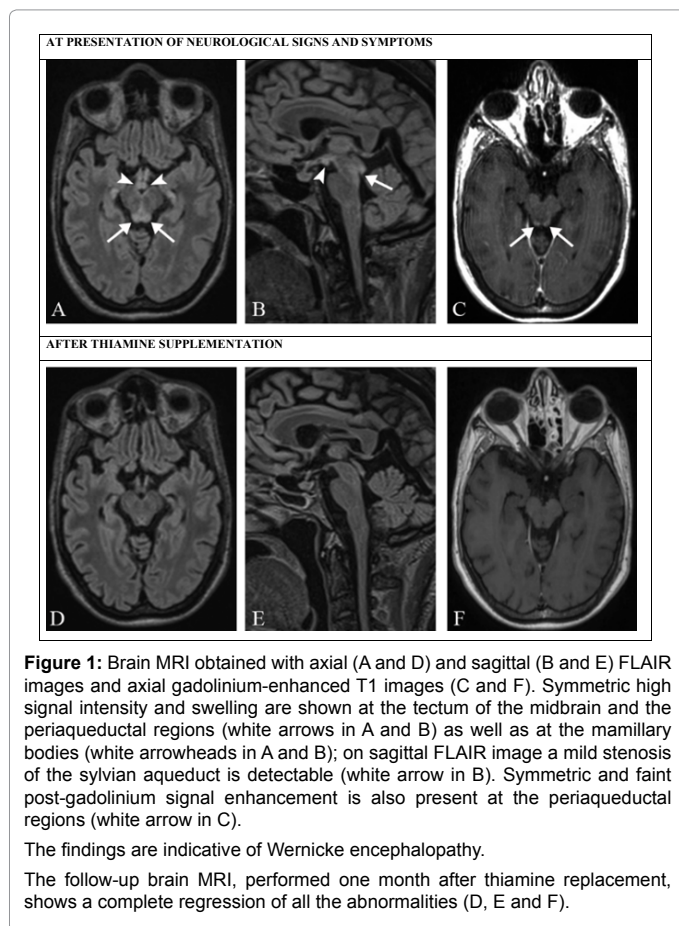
Brain MRI obtained with axial (A and D) and sagittal (B and E) FLAIR images and axial gadolinium-enhanced T1 images (C and F). Symmetric high signal intensity and swelling are shown at the tectum of the midbrain and the periaqueductal regions (white arrows in A and B) as well as at the mammillary bodies (white arrowheads in A and B); on sagittal FLAIR image a mild stenosis of the sylvian aqueduct is detectable (white arrow in B). Symmetric and faint post-gadolinium signal enhancement is also present at the periaqueductal regions (white arrow in C).
